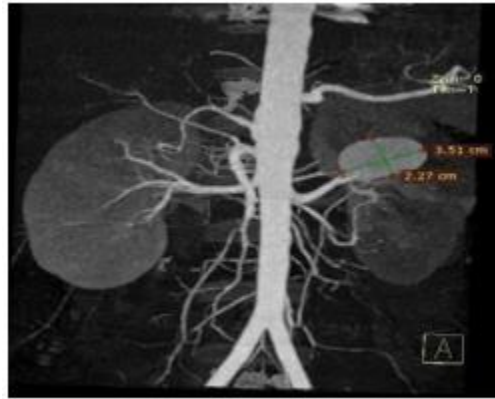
CT angiography revealed an 2.3x3.5 cm sized left renal artery saccular pseudoaneurysm
